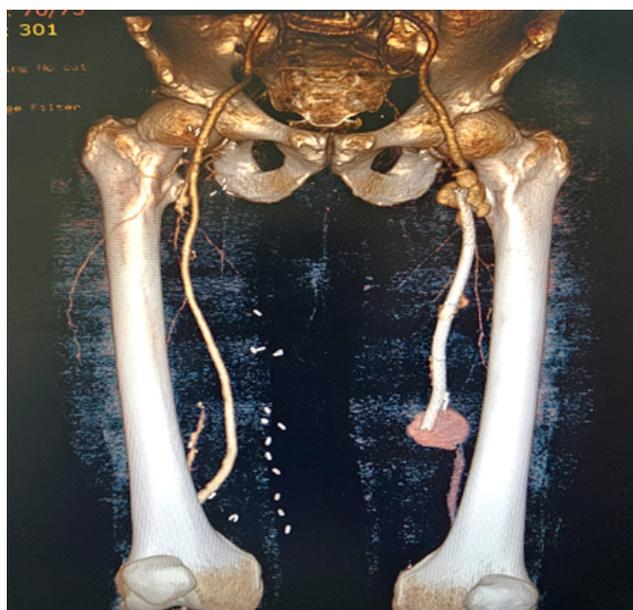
3 D Computed tomography angiography images of pseudoaneurysm
